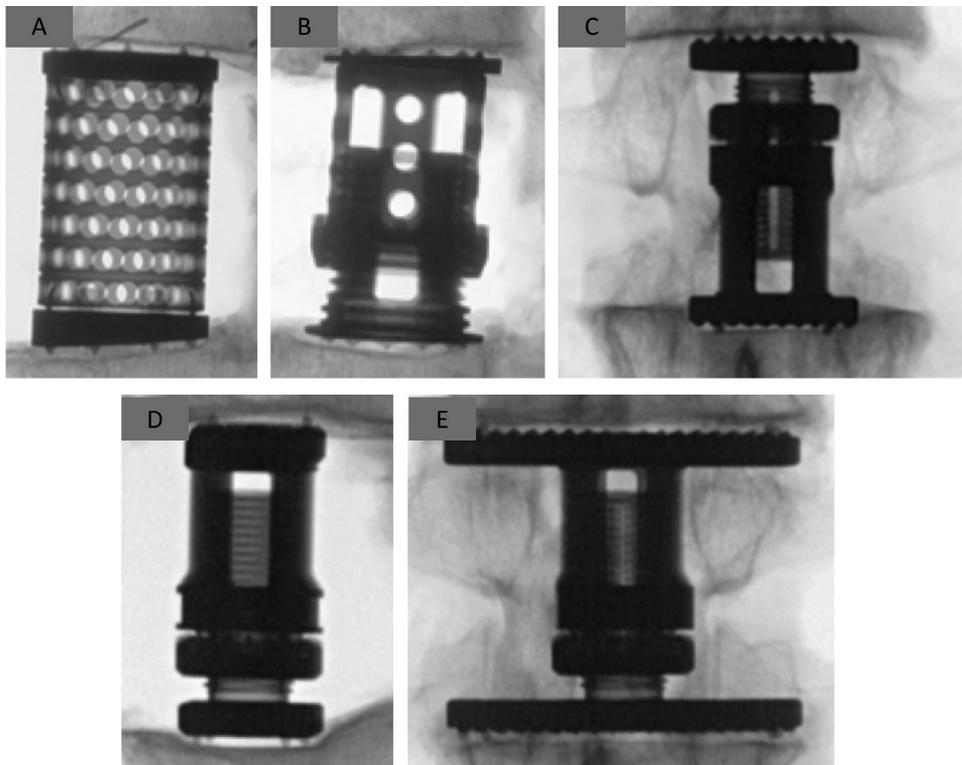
Radiographic examples of the various generations of interbody titanium cages for lumbar anterior column reconstruction. First generation cages were considered “static” (A). Second generation cages are considered “dynamic”, as they are expandable *in vivo* (B-E). Original designs of expandable cages have circular footprints (B, C); while newest iterations of expandable cages have wide, rectangular footprints that span the apophyseal ring (D,E). [A, B: reprinted with permission from *J Neurosurg Spine*. 2012 Oct;17(4):321-6¹⁶; C-E: reprinted with permission from *J Clin Neurosci*. 2014 Sep;21(9):1632-6²⁴].
